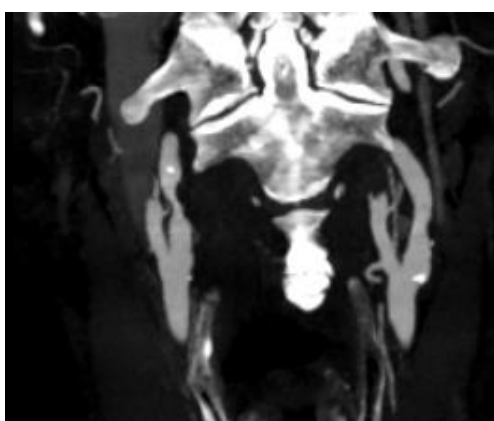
70-80% stenosis in right proximal ICA in CTA
